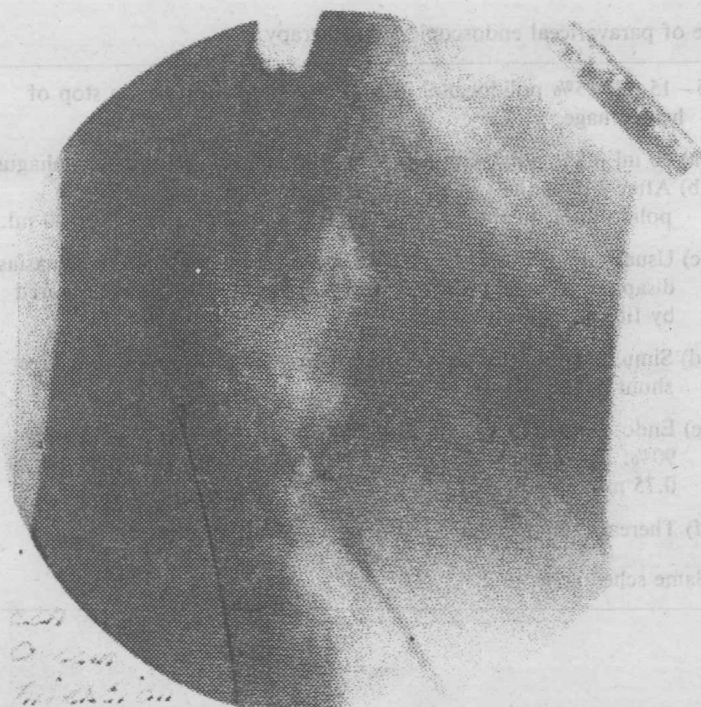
X-ray control of paravariceal or submucosal injection of sclerosant diluted by contrast medium; the X-ray picture is taken three minutes after injection; all injected substance is still localized in the injection areas and has not entered the systemic circulation.
